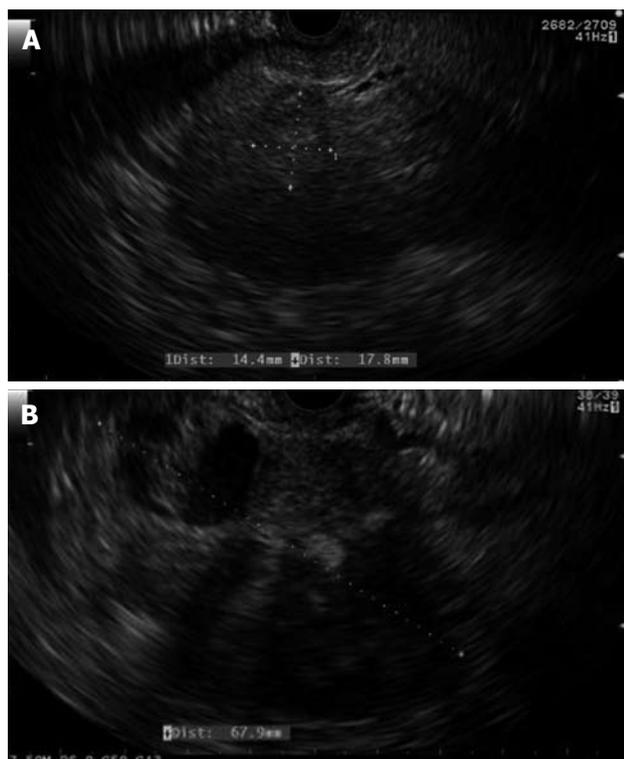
Endoscopic ultrasound image of the heterogenous, nearly isoechoic lesion in the left lobe of the liver (A) and the complex cystic mass in the tail of pancreas (B).
